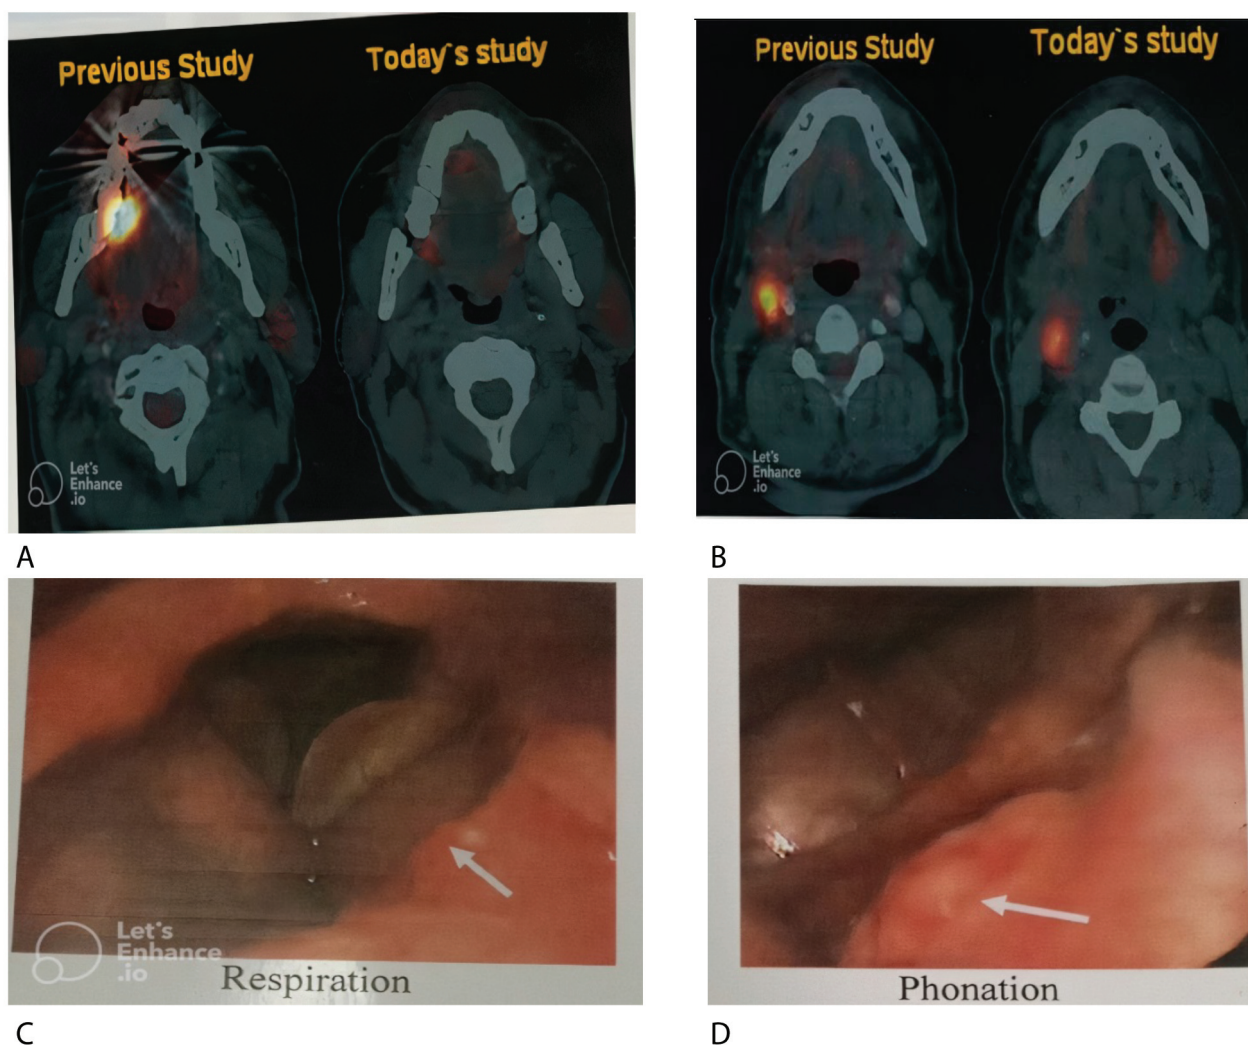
(A, B): Positron emission tomography and computed tomography (PET-CT) scan of a 59 years old male presented with tongue carcinoma shows complete resolution of previously enhancing hyper metabolic soft tissue lesion at the right lateral aspect of the proper hemi tongue, metabolic regression of the previously detected hyper metabolic upper deep cervical lymph node. (C, D): Telescopic video-laryngoscopy showed that multiple, irregular, reddish supraglottic swellings invade the upper part of the inner surface of the epiglottis, both ventricular bands, aryepiglottic fold, bilateral balloon shaped swellings of both vocal folds with unhealthy and markedly congested mucosa in a 49 years old male patient.
